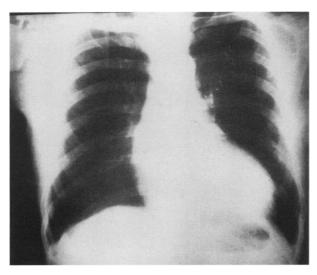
Preoperative chest radiograph showing cardiomegaly (most notably, left ventricular enlargement), and dilatation of the ascending aorta consistent with aneurysm.
